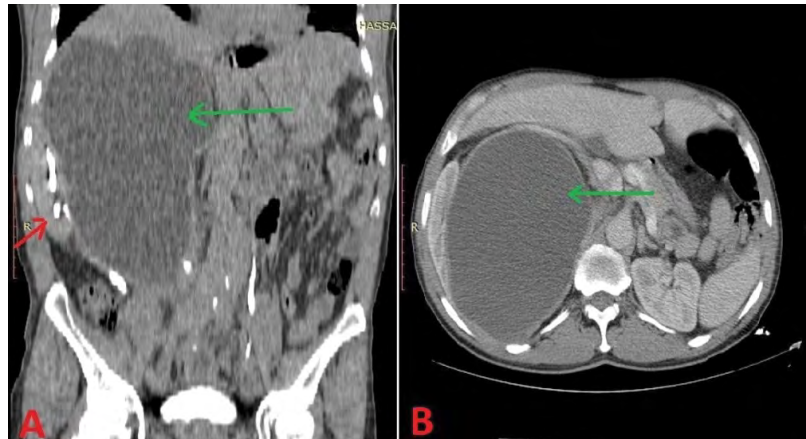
CT, frontal (A) and transverse (B) sections, showing a giant hydronephrosis of concerning the upper system (Green arrow) of a duplex system, the lower system compressed by the mass effect (Red arrow).
